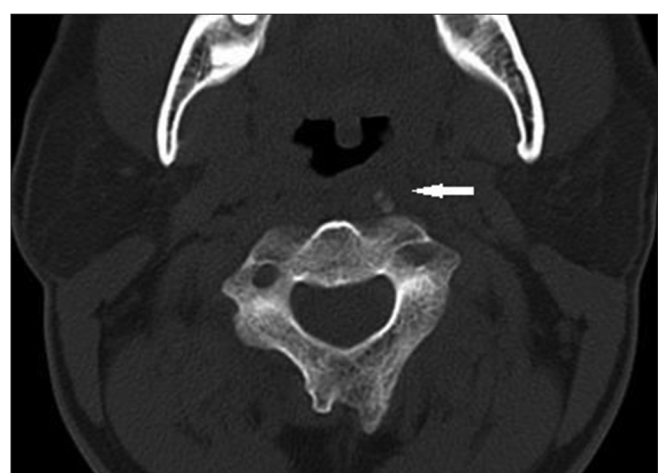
50 year old male with acute longus colli calcific tendinitis. Axial CT of neck at level of C1-2 showing calcifications (arrow) anterior to C1-2
